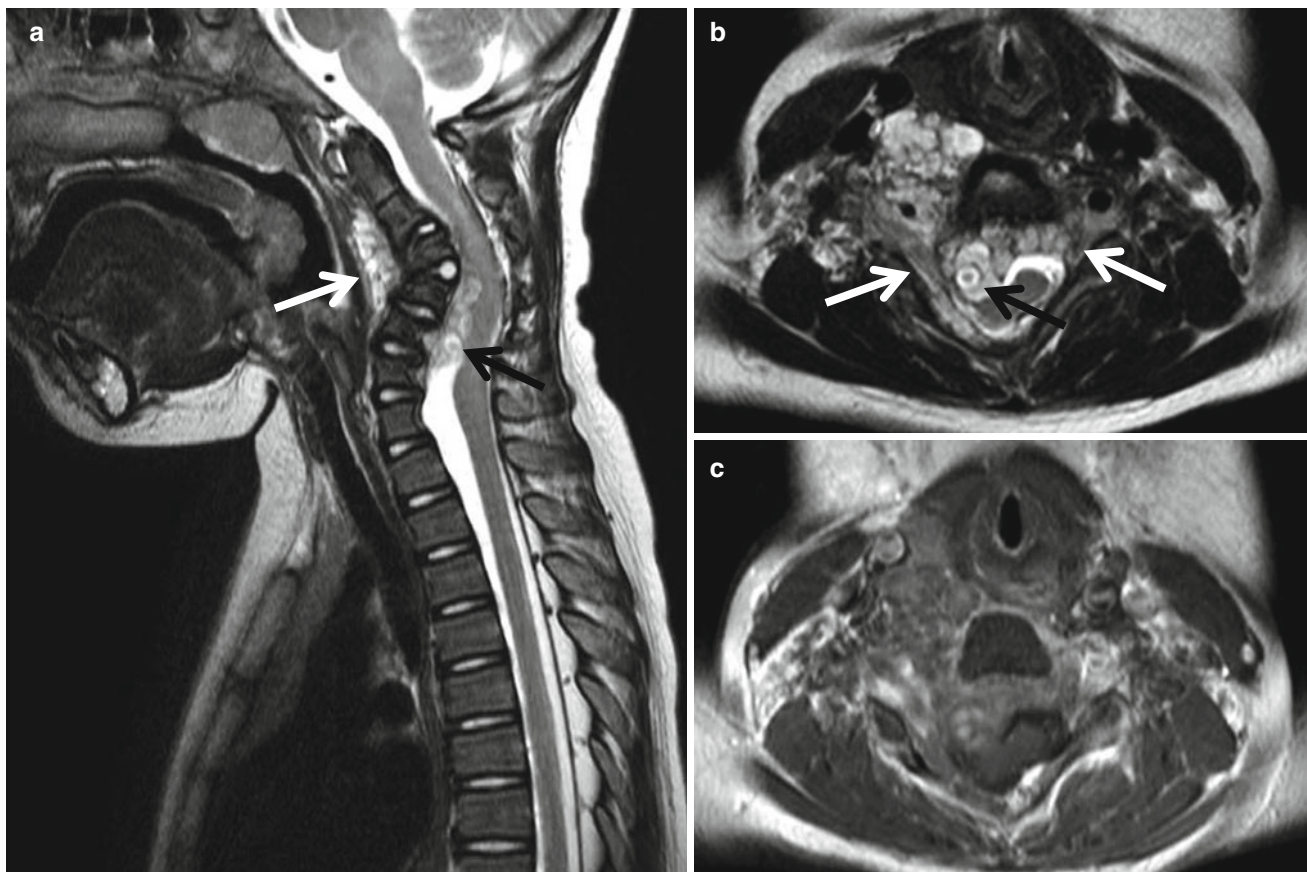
Plexiform neurofibromas in a patient with type 1 neurofibromatosis. (a) T2-weighted sagittal image shows heterogeneous mass (*black arrow*) anterior to the cord with widening of the distal CSF space suggesting IDEM in location. In addition, adjacent kyphotic cervical spine and prevertebral mass (*white arrow*) were noted. Increased intensity of the compressed cord is suggesting myelopathy, and the medulla
